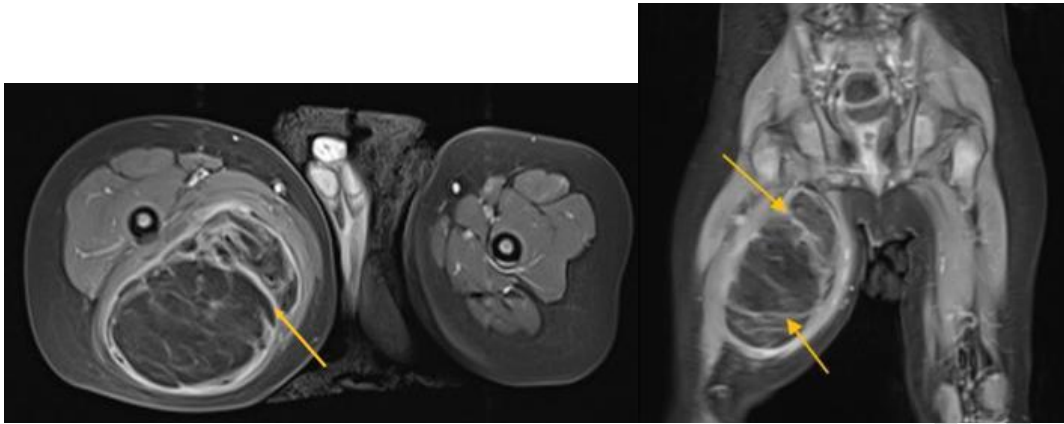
Thigh's MRI revealing a subaponeurotic intermuscular tumoral process with heterogeneous signal characteristics, and septa (yellow arrows).
